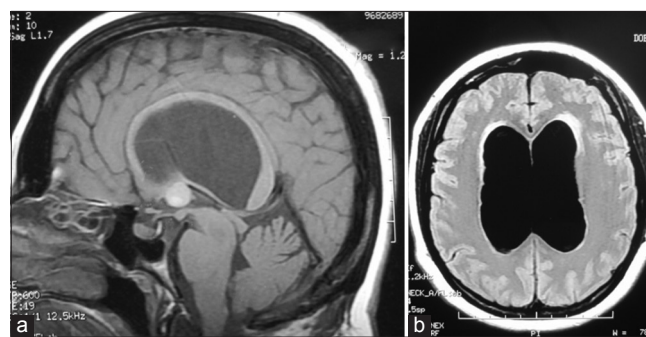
Preoperative magnetic resonance imaging views of the patient (a) Sagittal T1-weighted cerebral magnetic resonance imaging showing a third ventricular colloid cyst and significant hydrocephalus with ballooning of the corpus callosum. (b) Axial T1 view of the same patient
